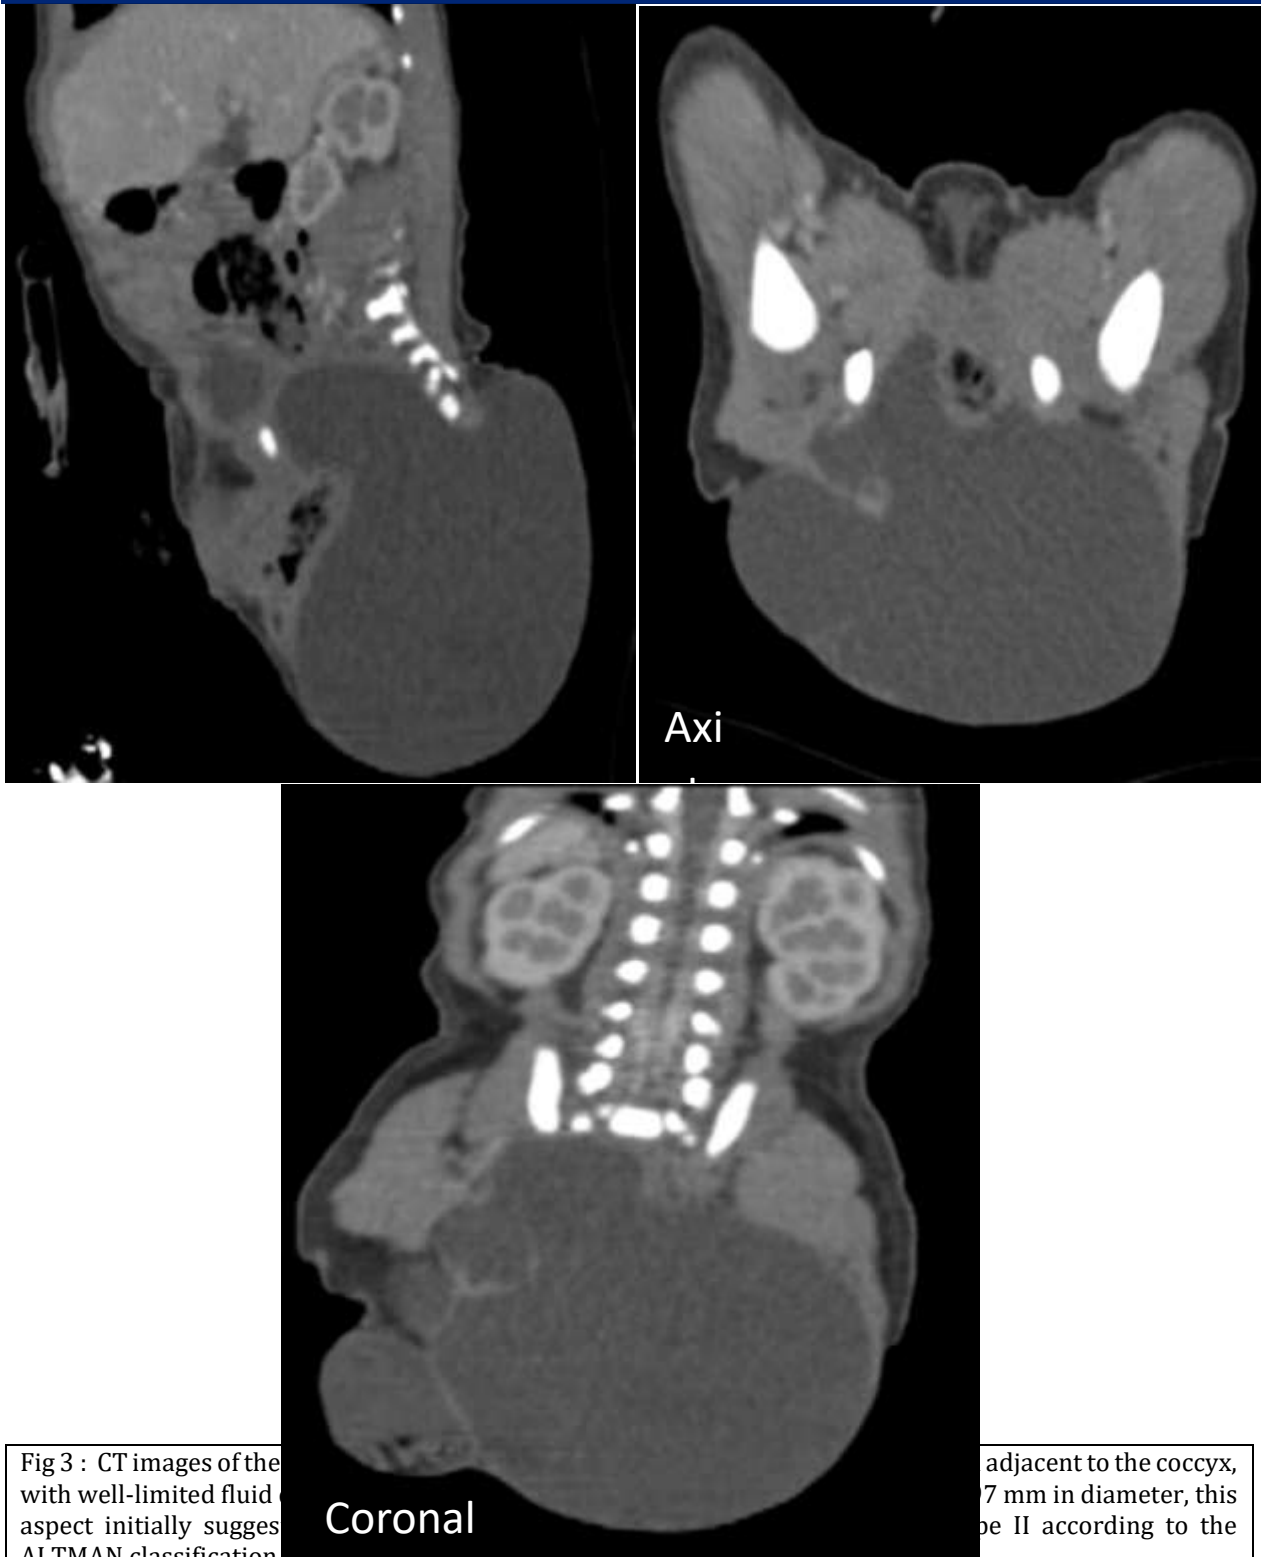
CT images of the pelvis showing a well-limited fluid-filled mass. This aspect initially suggests a cystic lesion according to the ALTMAN classification.
